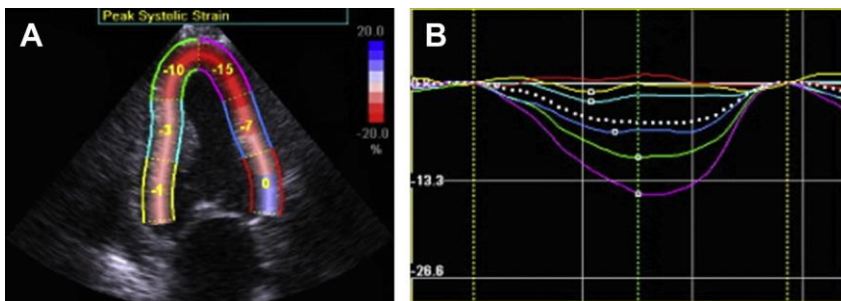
Echocardiographic longitudinal strain measurements in a patient with cardiac amyloidosis. Parametric image of longitudinal strain superimposed over a long axis echocardiography view (A) reveals reduced longitudinal strain values (normal, less than -16), with relative sparing of apical segments. Two-dimensional plot of strain in color-coded cardiac segments (B) again demonstrates markedly reduced strain in basal segments with preserved strain in apical segments.
